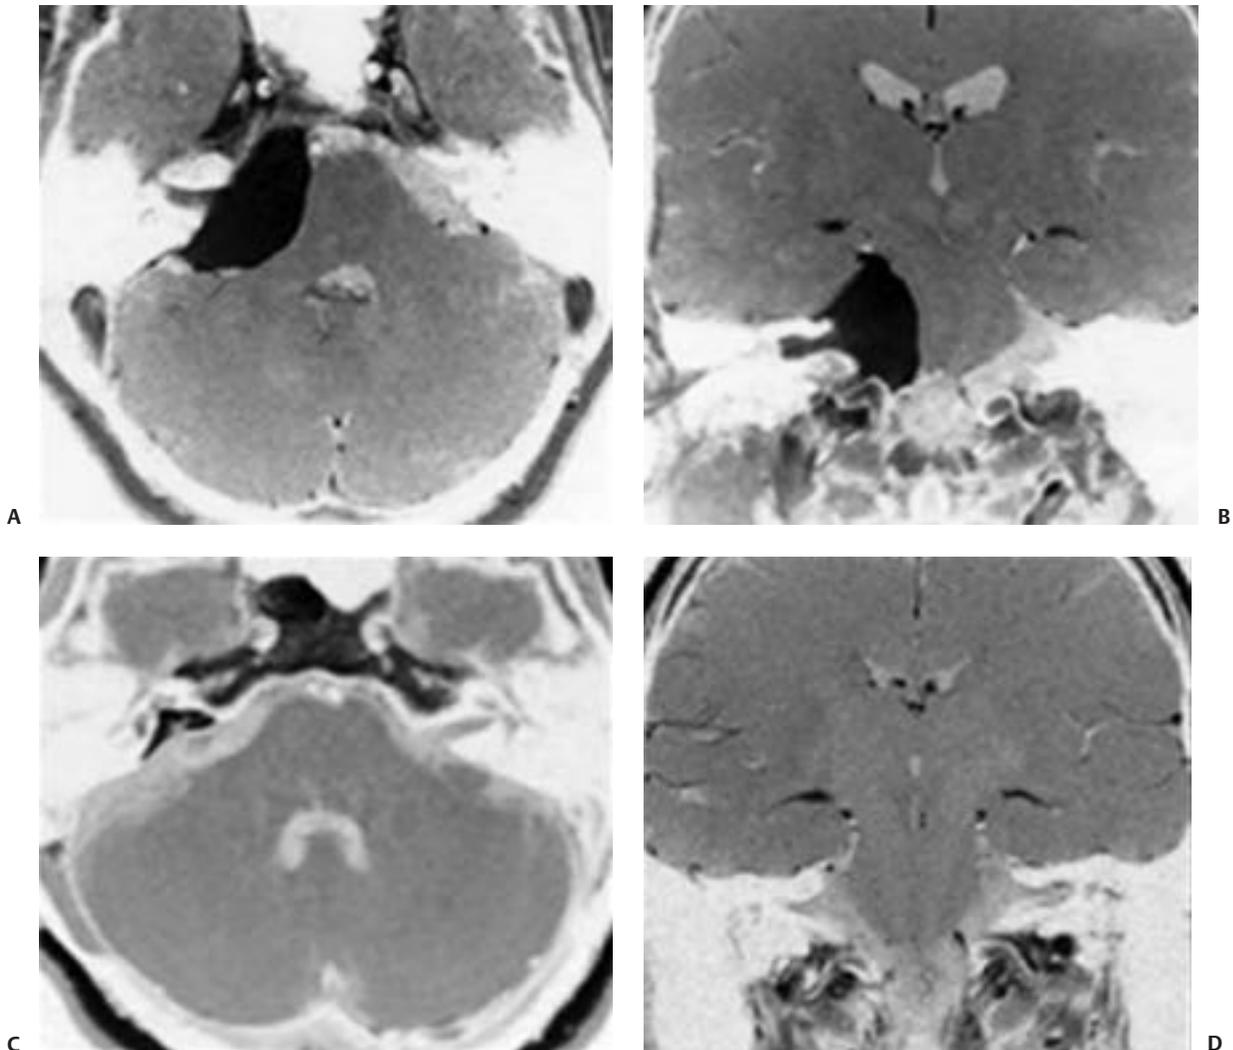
(A,B) Preoperative and (C,D) postoperative T1-weighted magnetic resonance imaging of a meningioma with extension into the internal acoustic meatus. The fat tissue used to seal the opened IAM is seen as a hyperintense signal.
